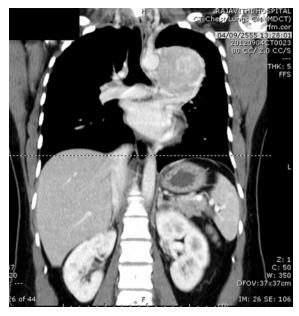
CT chest and upper abdomen: Left anterior mediastinal mass with normal adrenal glands.
